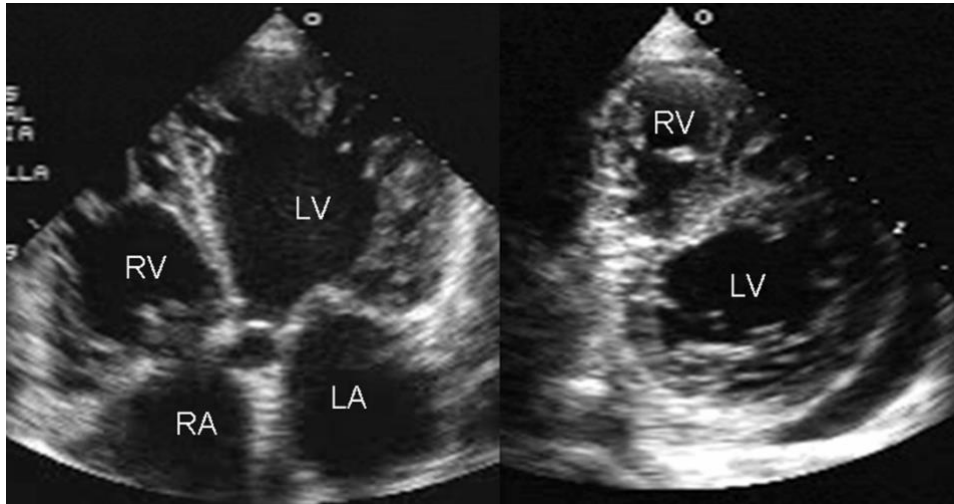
Transthoracic two-dimensional echocardiogram in apical four chamber and parasternal short axis at the level of both ventricles demonstrate dilatation, deep trabeculae and intertrabecular recesses in the inferior, lateral, anterior walls, middle and apical portions of the septum and apex of the left ventricle. The right ventricle also shows evidence of noncompaction. A posterolateral pericardial effusion is also present (22).
